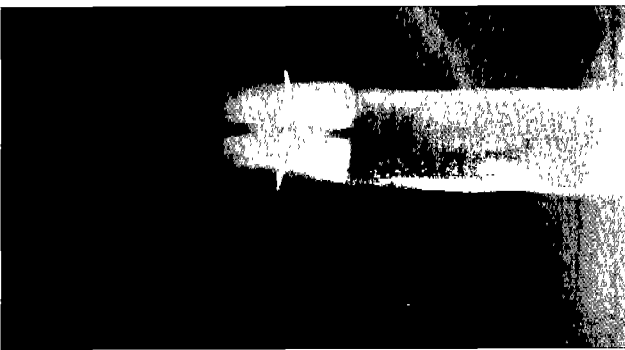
Radiograph two and one half years after removing the bone plate. 3/29/94.
